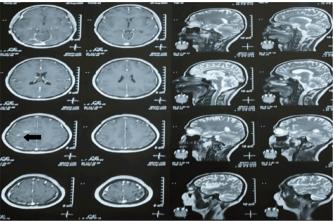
MRI of the brain (axial and sagittal views) showing multiple acute ischaemic infarcts (arrows), suggestive of CNS vasculitis in the setting of SLF.
